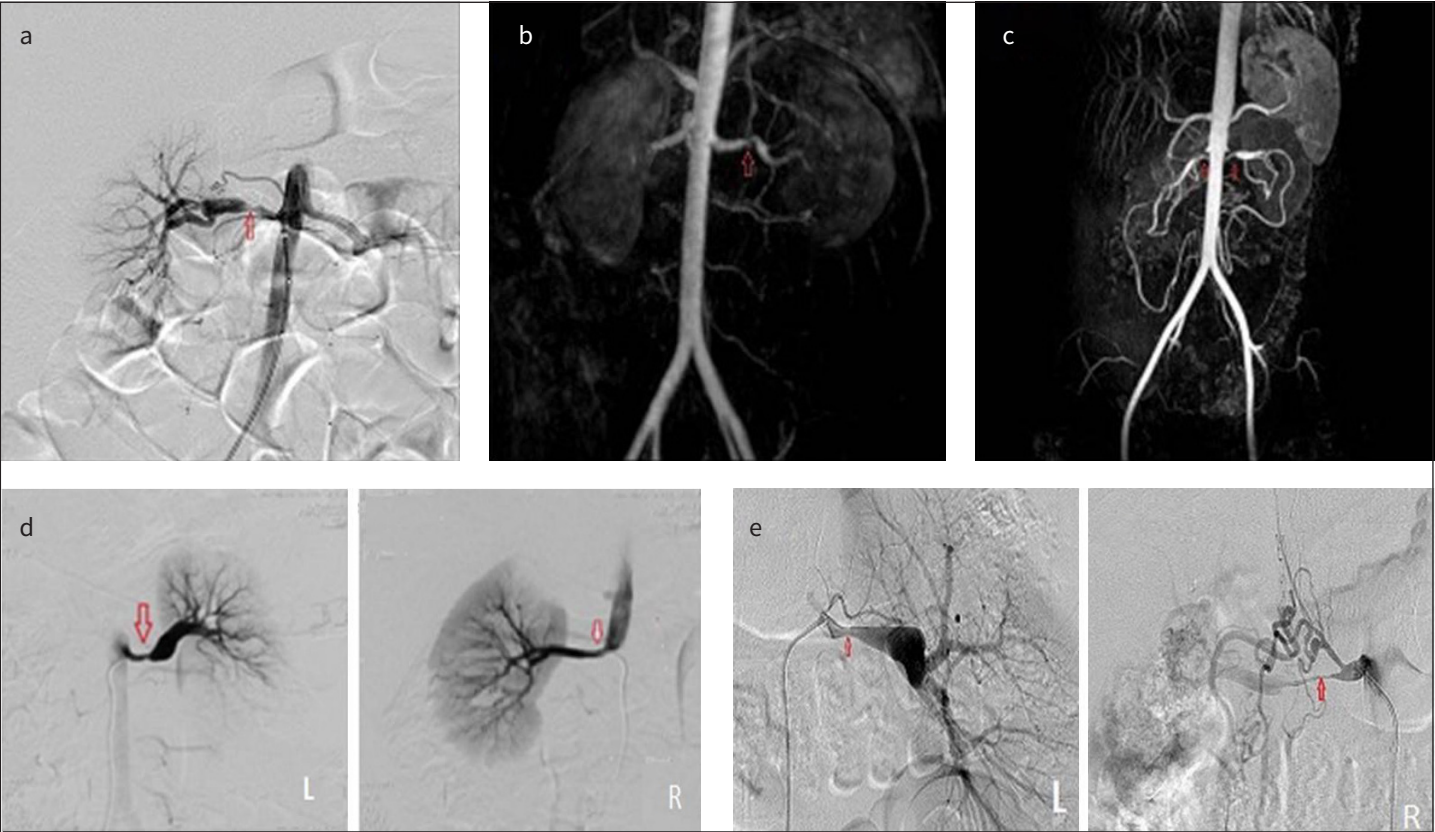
a-e. a) Conventional renal angiography showed stenosis of the left renal artery (Case 1). b) CT angiography showed stenosis of the right renal artery (Case 2). c) CT angiography showed bilateral renal artery stenosis (Case 3). d) Conventional renal angiography showed bilateral renal artery stenosis (Case 4). e) Conventional renal angiography showed bilateral renal artery stenosis (Case 5).
